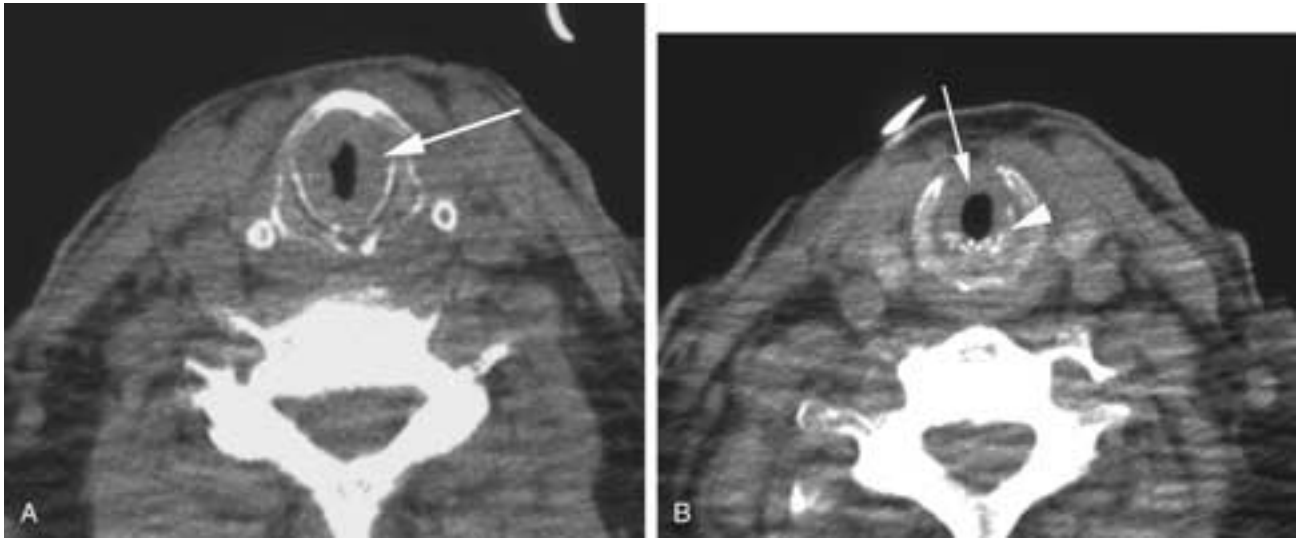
Submucosal amyloid infiltration. Axial noncontrast CT. A, In the subglottic position there is concentric narrowing (*arrow*) of the airway. At this level there should be no soft tissue within the cricoid ring. B, Slightly caudal to A. Note again the soft tissue (*arrow*) concentrically narrowing the airway. Note the calcifications (*arrowhead*) more posteriorly.
